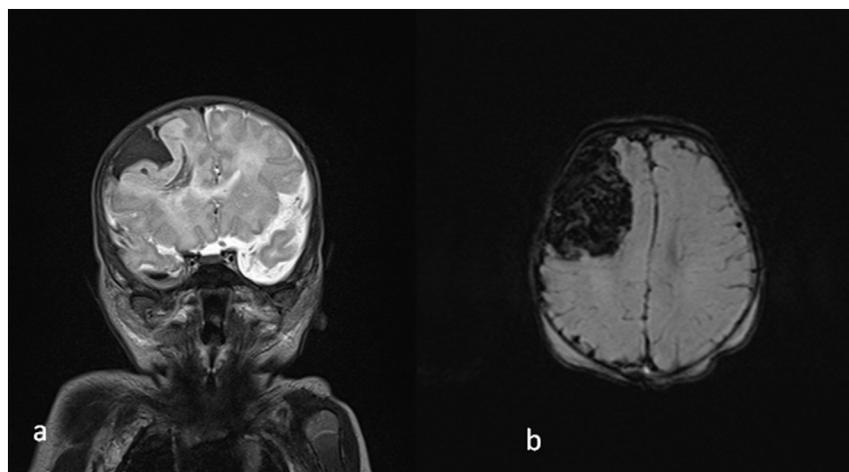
Term neonate with focal seizures and lethargy. a) On this coronal T2-weighted image, a large area of low signal intensity (dark) in the right frontal cortex is identified corresponding to a subpial hematoma. The underlying brain tissue is compressed and has mixed low and high signal intensity corresponding to a swollen brain parenchyma with haemorrhagic content. b) Susceptibility weighted imaging of the same neonate confirming large area of brain haemorrhage in the right frontal region. Despite extensive work-up, no underlying cause was found.
